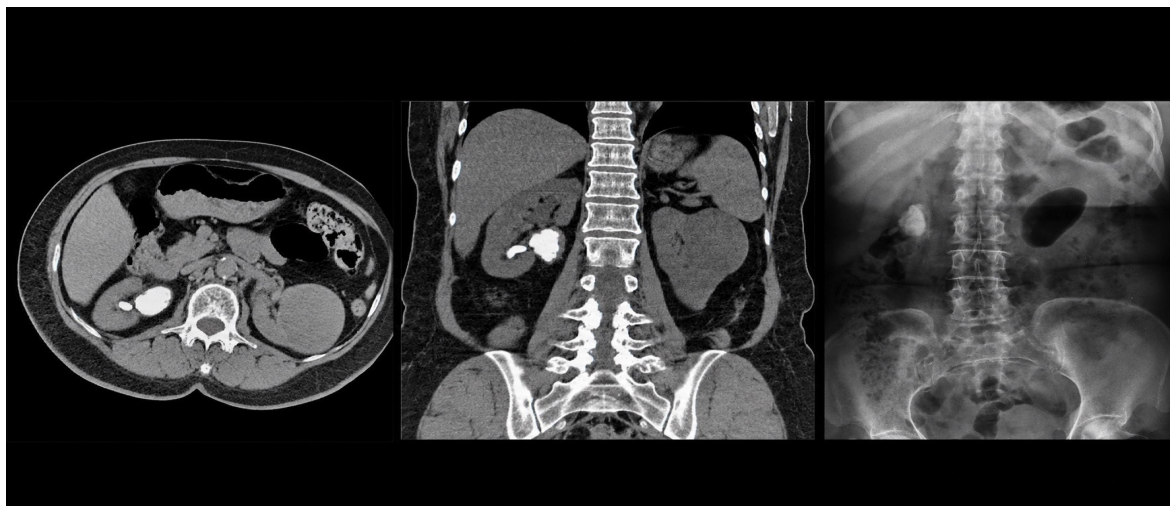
Preoperative computed tomography scan showing dense renal pelvis and lower-pole opacity mimicking a staghorn calculus.
